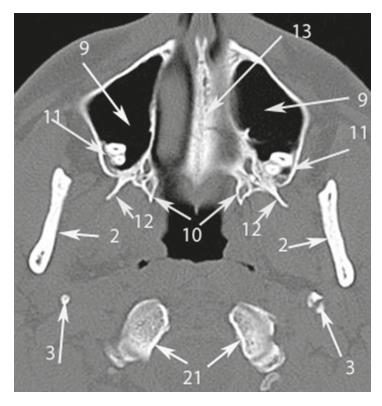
Axial CT scan at the middle third of the maxillary sinus. *Numbers* with *arrows* denote the following anatomical structures: 2 – inner surfaces of the mandibular rami; 3 – styloid process of the temporal bone; 9 – maxillary sinus; 10 – medial pterygoid plate of the sphenoid; 11 – apices of the teeth roots located in the maxillary sinus; 12 – lateral pterygoid plate of the sphenoid; 13 – nasal septum; 17 – the hard palate; 21 – cervical vertebrae.
